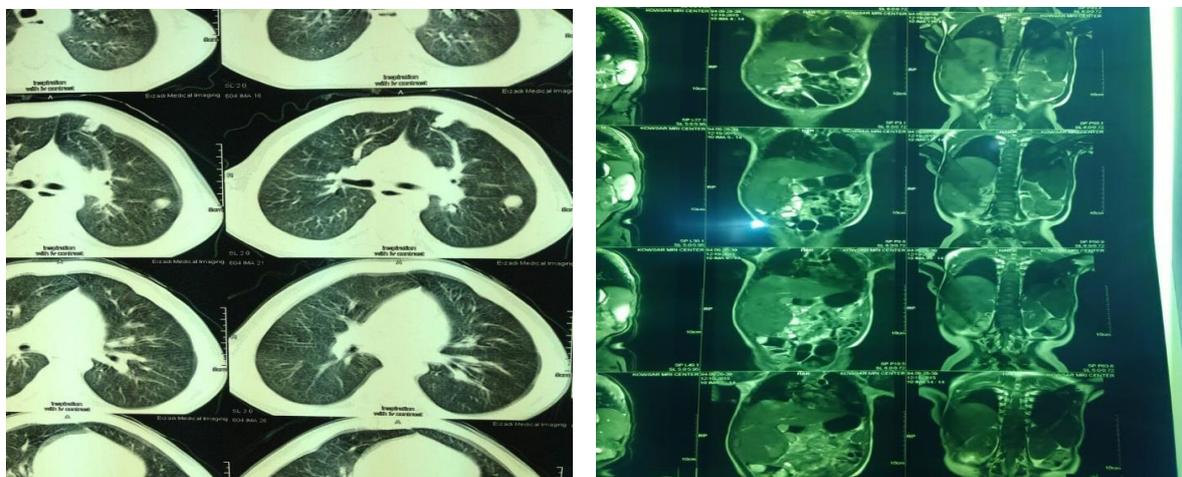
CT scan showing mass in the liver and lung.
